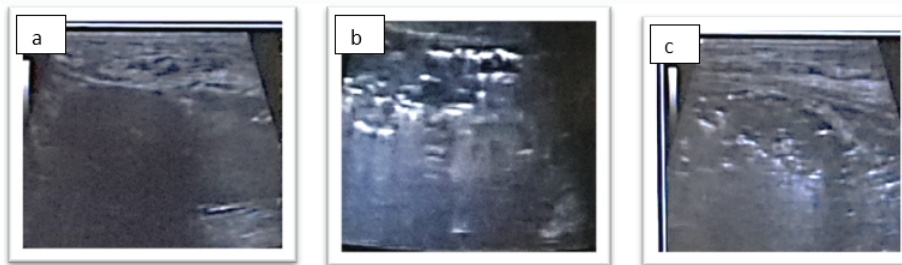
Hyperechoic intra scrotal ultrasound images predominantly on the left. The testes are intra scrotally, homogeneous without parenchymal anomaly. There is an infiltration of the soft parts with a collection of medium abundance especially on the right.
